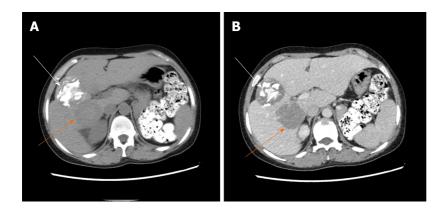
The third case of abdominal enhancement computed tomography. A: The high-density shadow indicated by the white arrow is a cystic hydatid lesion, while the low-density shadow indicated by the orange arrow is an alveolar hydatid lesion; B: The blue arrow indicates the retrohepatic inferior vena
